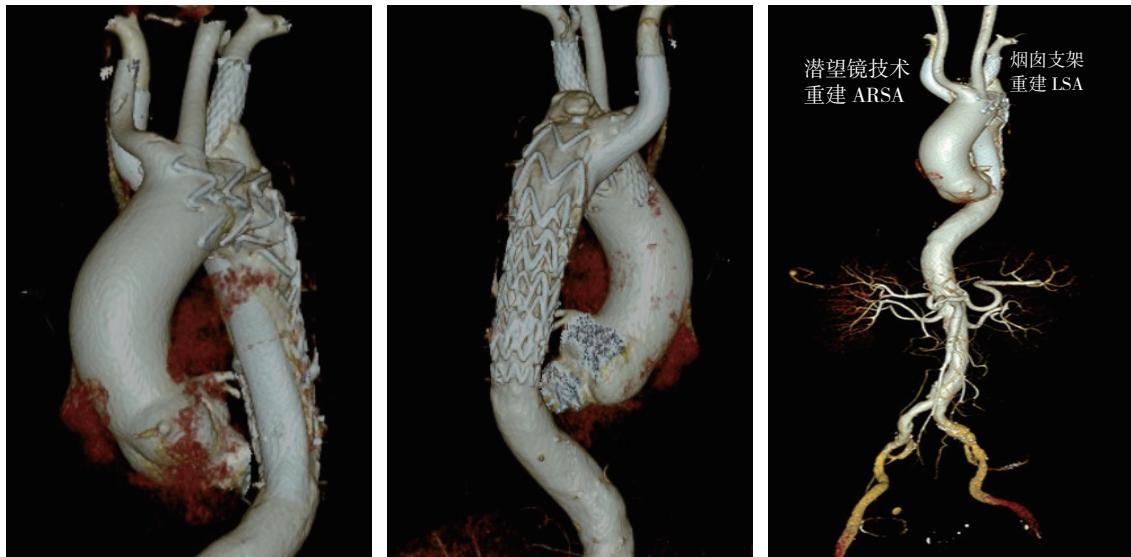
使用烟囱技术重建 LSA, 潜望镜技术重建 ARSA 患者的术后 CTA 三维重建图像 (TBAD 被完全封堵, 弓部分支动脉通过重建, 均保持通畅)
